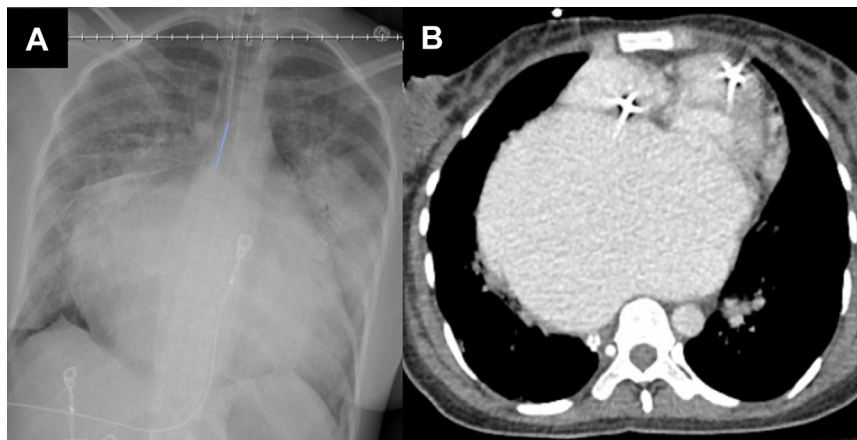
Imaging shows a gigantic left atrium and pulmonary edema. A, Anterior-posterior chest radiograph on hospital day 4. B, Computed tomography of the abdomen and pelvis with contrast from hospital day 7.
